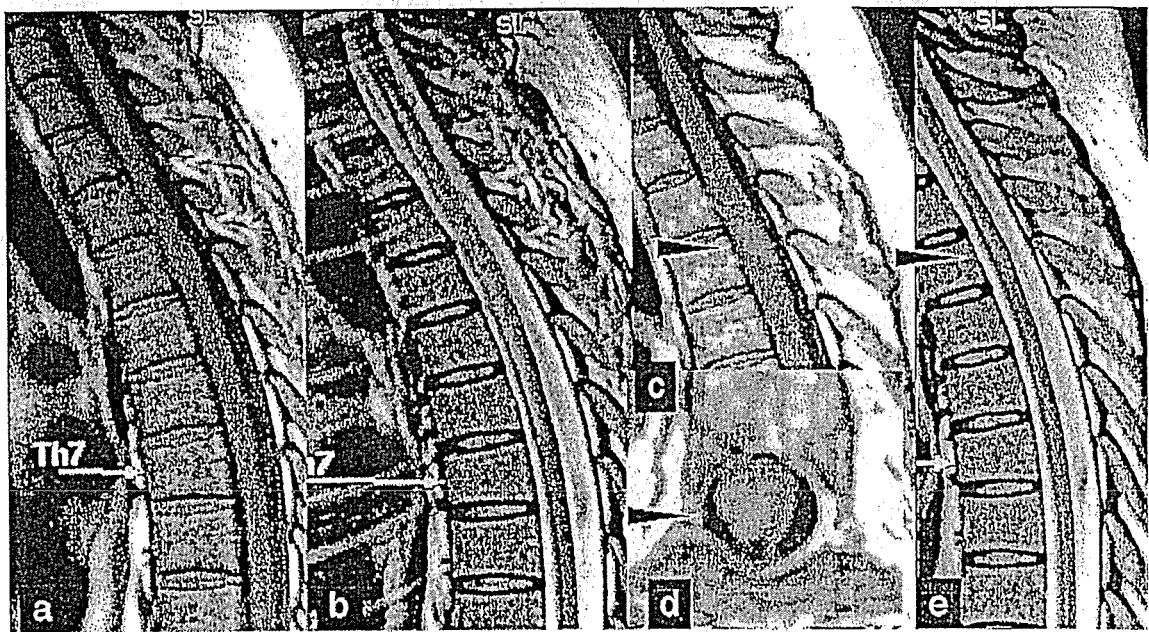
MRI before (a–d) and after (e) treatment (patient 2). (a) Sagittal T1WI demonstrates swelling of the cord from T3 to T6. (b) Sagittal T2WI shows high signal intensity in the same levels. (c, d) Post-contrast sagittal (c) and axial (d) T1WI show focal enhancement at the T4 level (arrowhead). (e) After the second treatment, sagittal T2WI showing decreased swelling with residual high signal intensity of the spinal cord.
